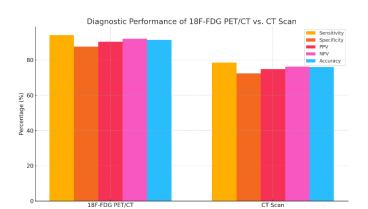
Lesion Detection Rates: PET/CT vs CT scan
